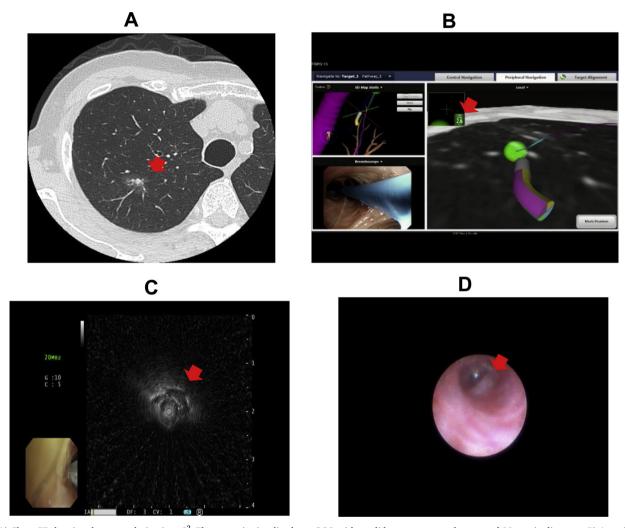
A) Chest CT showing the cancer lesion in rt S². The tumor is visualized as a GGO with a solid component, and measured 20 mm in diameter. B) A navigational bronchoscopy image using superDimension. The green ball represents the right upper nodule at rt S² in the apical segment. The red arrow shows the alignment of the guide sheath with the target at 2.8 cm distance. C) R-EBUS image of the tumor. The red arrow shows the tumor lesion. D) Image of the peripheral-type lung cancer lesion as visualized by the COF. The red arrow shows the tumor.
